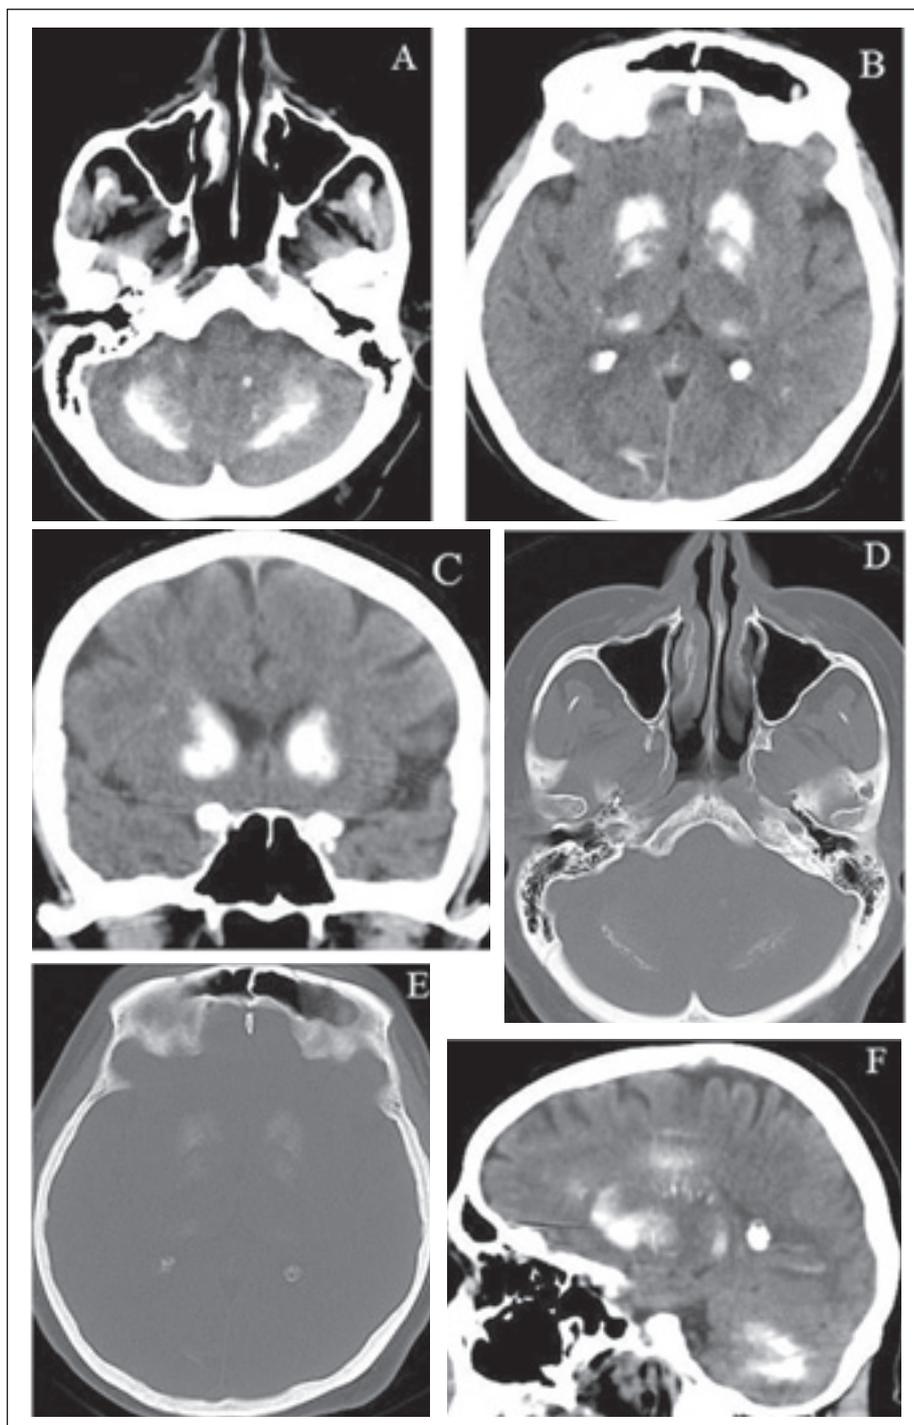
Brain CT. (A, B) Axial views, (C) coronal view, (F) sagittal tissue view, (D, E) axial bone window. Bilateral symmetric hyperdense calcification areas.
